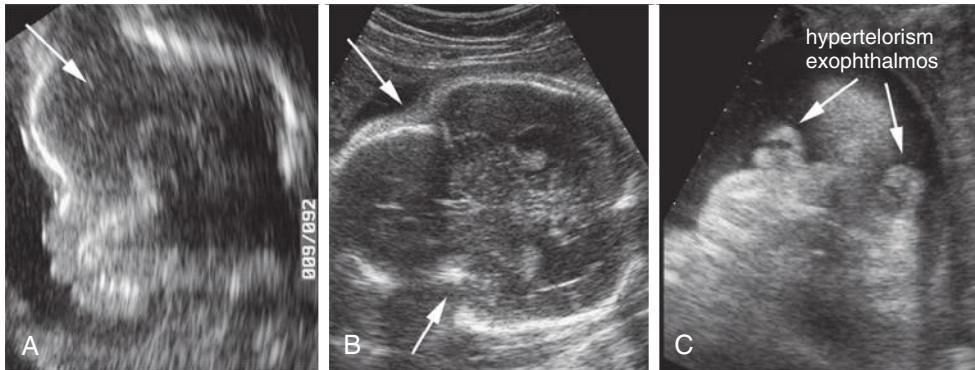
Antenatal sonogram from the case demonstrated in Figure 10-27B: A and B, Sagittal and axial sonograms demonstrating the cloverleaf skull (arrows). C, Exophthalmos and hypertelorism.
